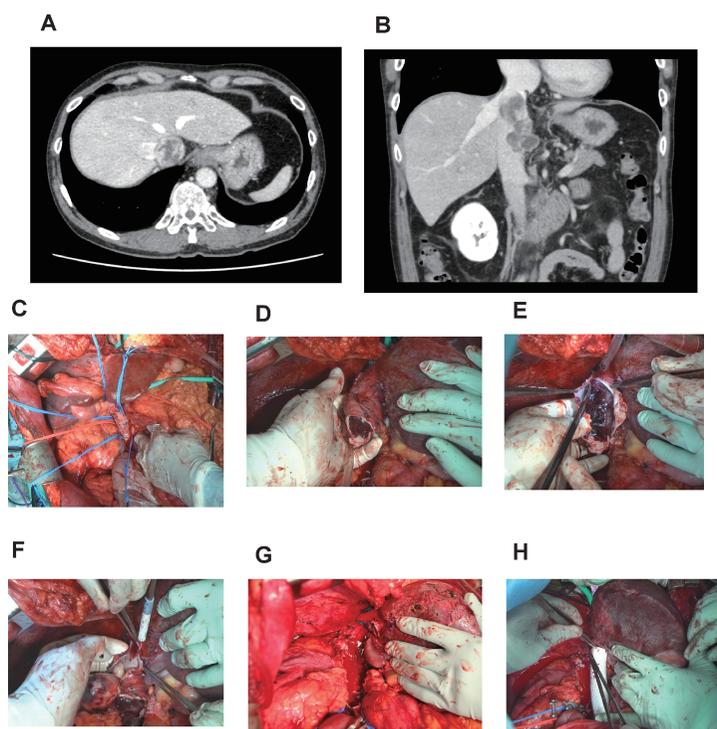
A case of leiomyosarcoma originating from the left wall of the inferior vena cava (IVC). The computed tomography images from the axial (A) and coronal (B) scans indicate a tumor thrombus in the IVC blocking hepatic venous flow. After taping the right renal artery and vein, the left renal vein, and the IVC upstream and downstream of the tumor (C). The upstream IVC was transected under extracorporeal circulation (D). The IVC was incised longitudinally on the opposite side of the tumor (E). The tumor thrombus was pulled out and inverted (F). After tumor resection (G). After reconstruction of the defective IVC with a prosthetic graft (H).
